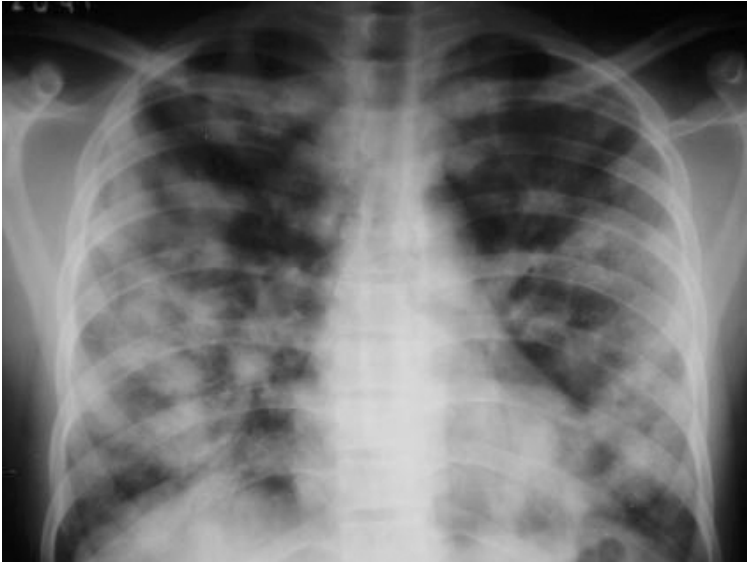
Chest X-rays showing diffuse bilateral confluent pulmonary nodules
